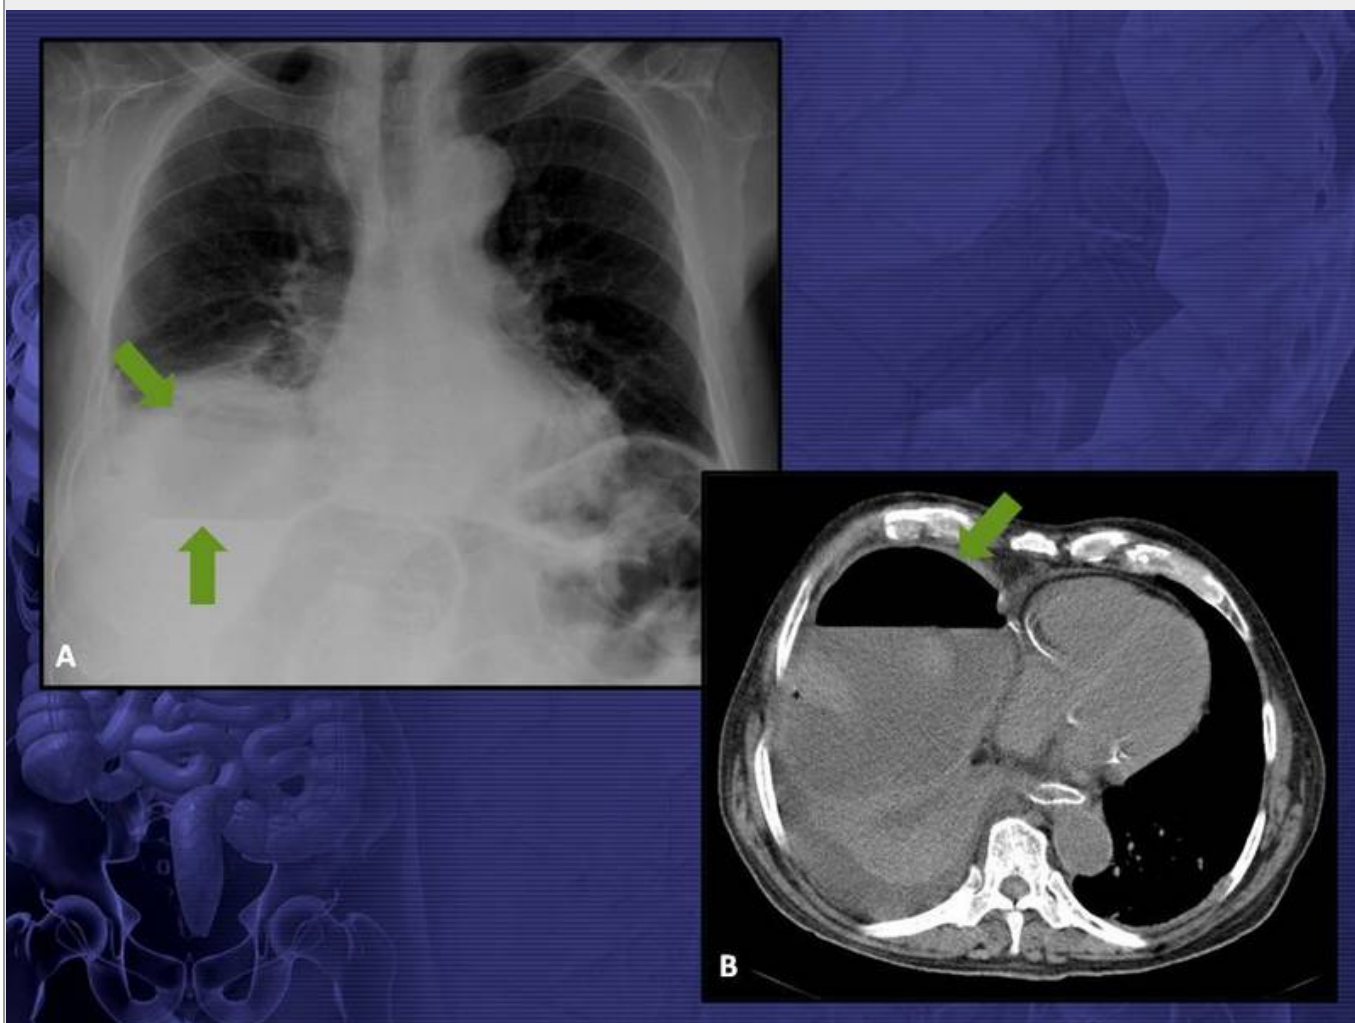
(A) Frontal chest radiograph reveals an elevated right hemidiaphragm, below which there is an air fluid level, projecting at the site of the liver (arrows). (B) CT scan confirmed the diagnosis of a liver abscess.
